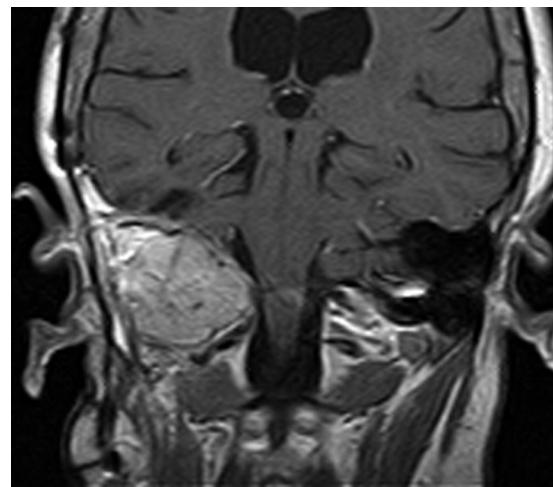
MRI before radiotherapy of the fifth case.
